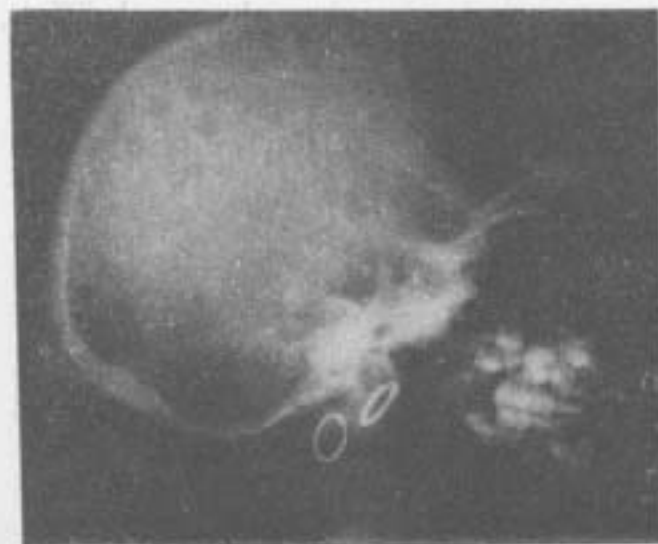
ray skull showing multiple osteopathic lesions and decreased bone density.
